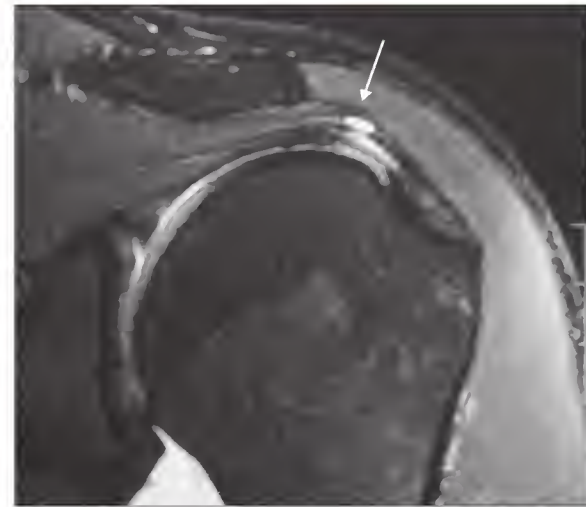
Magnetic resonance image of complex rotator cuff pathology. The image shows a partial articular surface rotator cuff tear along with a laminar defect and small cyst in the distal supraspinatus tendon (arrow).
